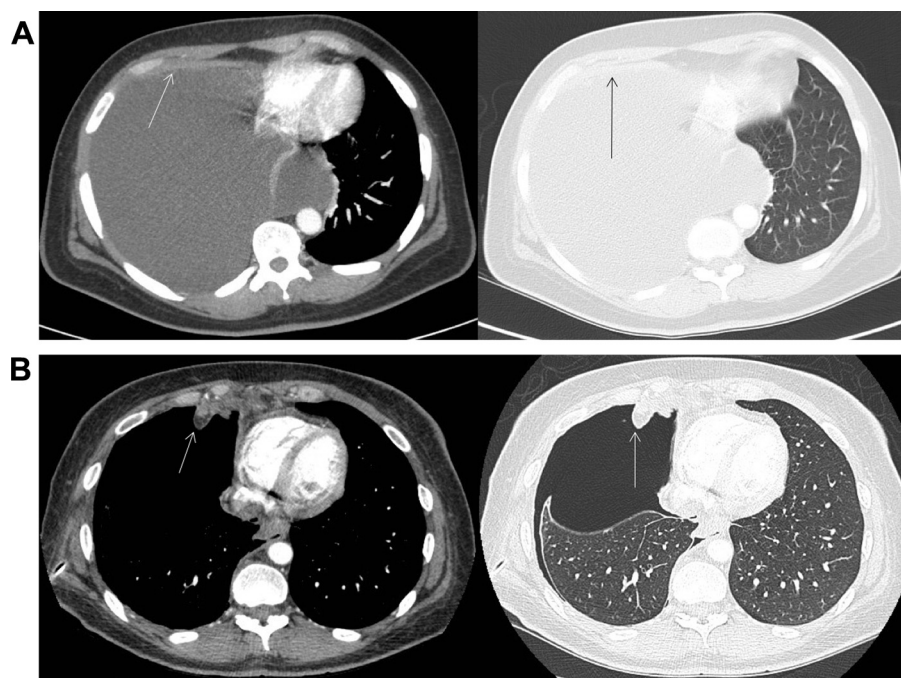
A, CT imaging showing large pleural effusion with possible anterior pleural thickening (arrow). B, Axial CT images of the thorax showing unexpanded lung revealing marked pleural nodularity (arrows).
